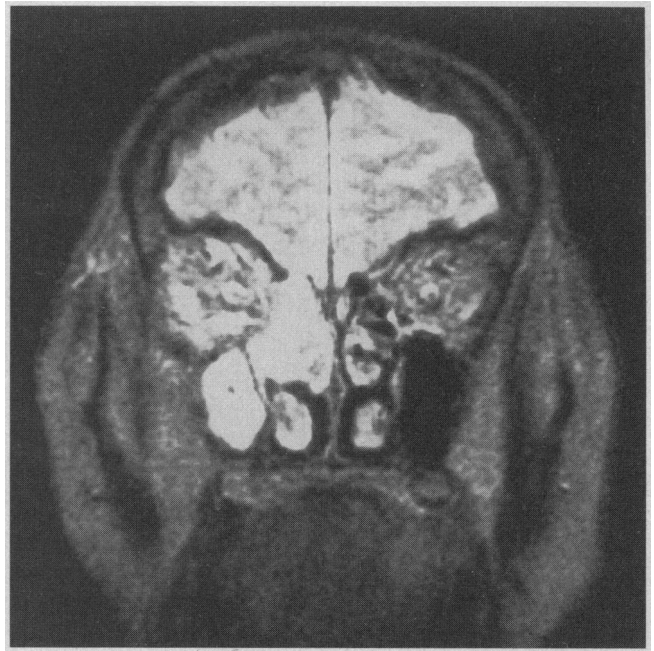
Magnetic resonance imaging of the head showing right-sided maxillary and ethmoidal sinusitis. The high signal intensity on T2 imaging is suggestive of an inflammatory process.
